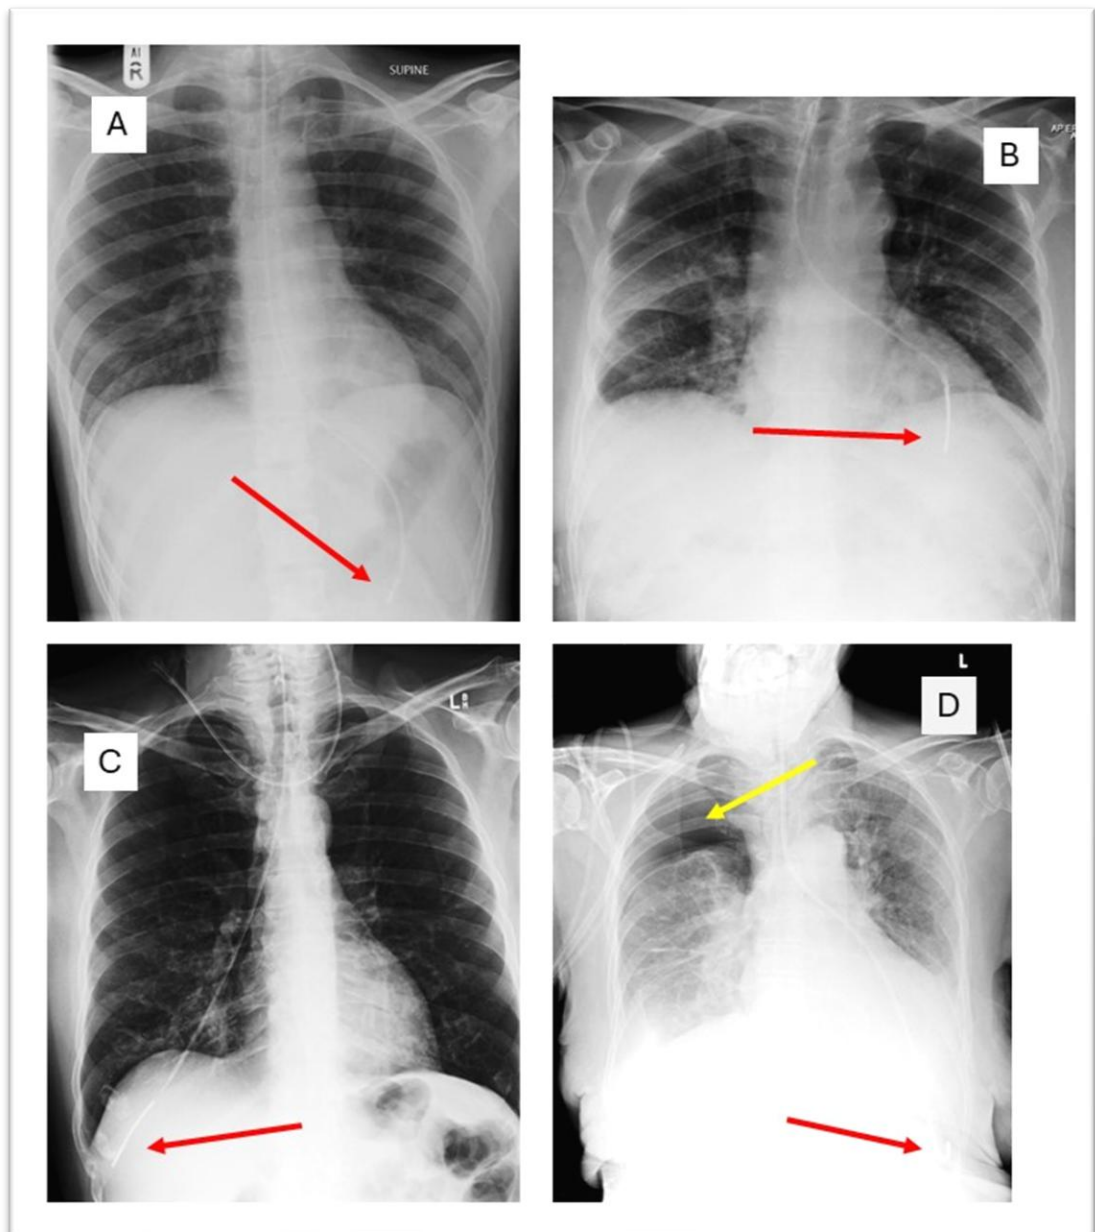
Correctly sited nasogastric tube. The tip is below the diaphragm and crosses the midline below the diaphragm. B: NG tube misplaced within the left main bronchus. It crosses the midline well above the diaphragm. C: Misplaced tube with tip in lower lobe of the right lung. D: Misplaced tube in lower lobe of left lung, with large right pneumothorax (yellow arrow) likely from previous failed attempts prior to x-ray (Bickle *et al.*, 2014).
